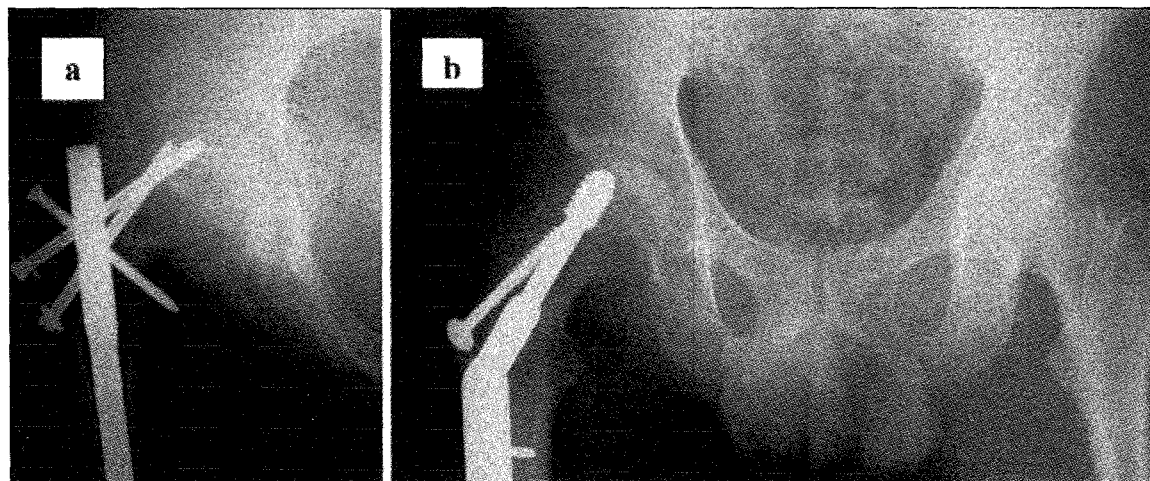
a- Pre-revision radiograph showing severe coxa vara and screw cut-out. b- Post-revision radiograph showing non-ideal position of sliding compression screw in the supero-lateral segment of the femoral head.
